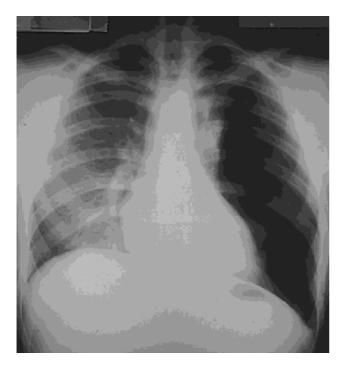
Chest radiograph (Case 2) showing giant bulla in left upper lobe but no pneumothorax.
